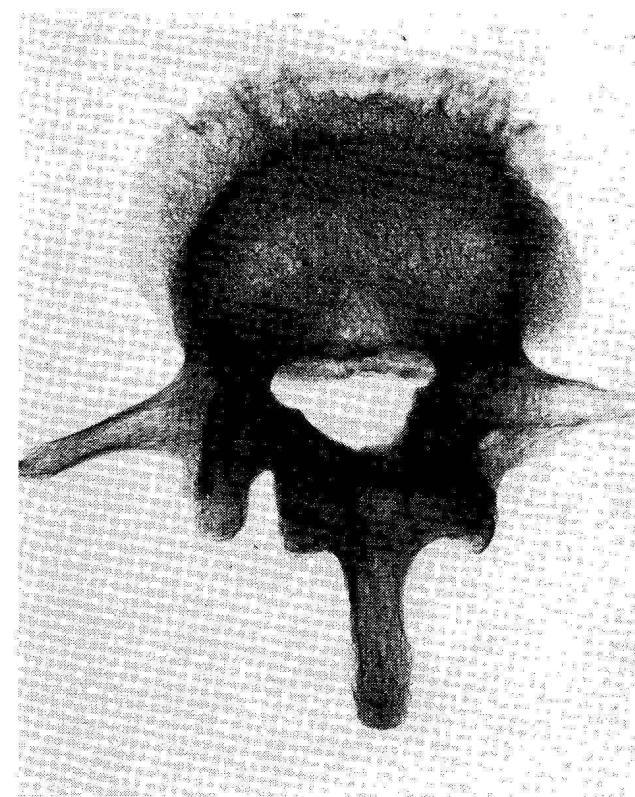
Roentgenogram. Deforming spondylosis of the 3rd degree of the 12th thoracic vertebra (spondylosis deformans gravis vertebrae thoracalis XII). Burial No. 143.
